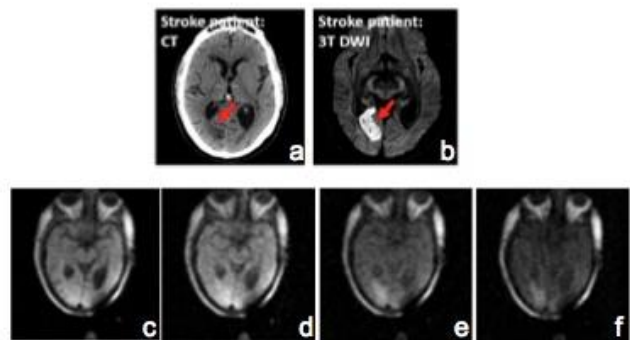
CT, 3T DWI MRI and FFC MRI images from a 67 year old male admitted with a right occipital infarct. a) CT at 24 hours after onset, b) 3T DWI image at 78 hours after onset c-f) FFC-MRI inversion-recovery images at the level of the lesion at 200mT, 50mT, 2mT and 0.2mT respectively (75 hours after onset).
